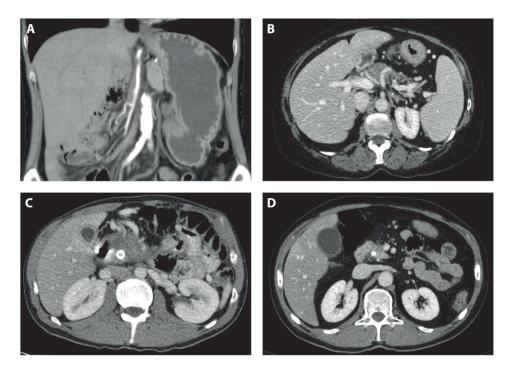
CT imaging of various scenarios of RFA and IRE eligibility
